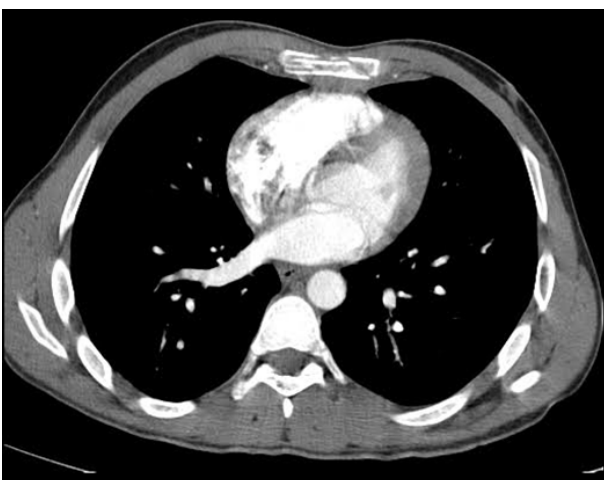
Axial contrast-enhanced CT image of the chest demonstrating a fracture of the manubrium sterni, characterized by cortical irregularity and surrounding soft tissue edema, consistent with acute traumatic injury
